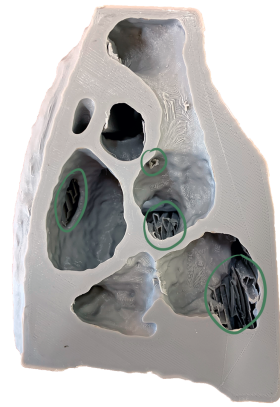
Result of the printing of the left section of the hollow model made with the CT scan of the heart of the patient with ToF. The green circles highlight the supports that could not be removed. Right view.
